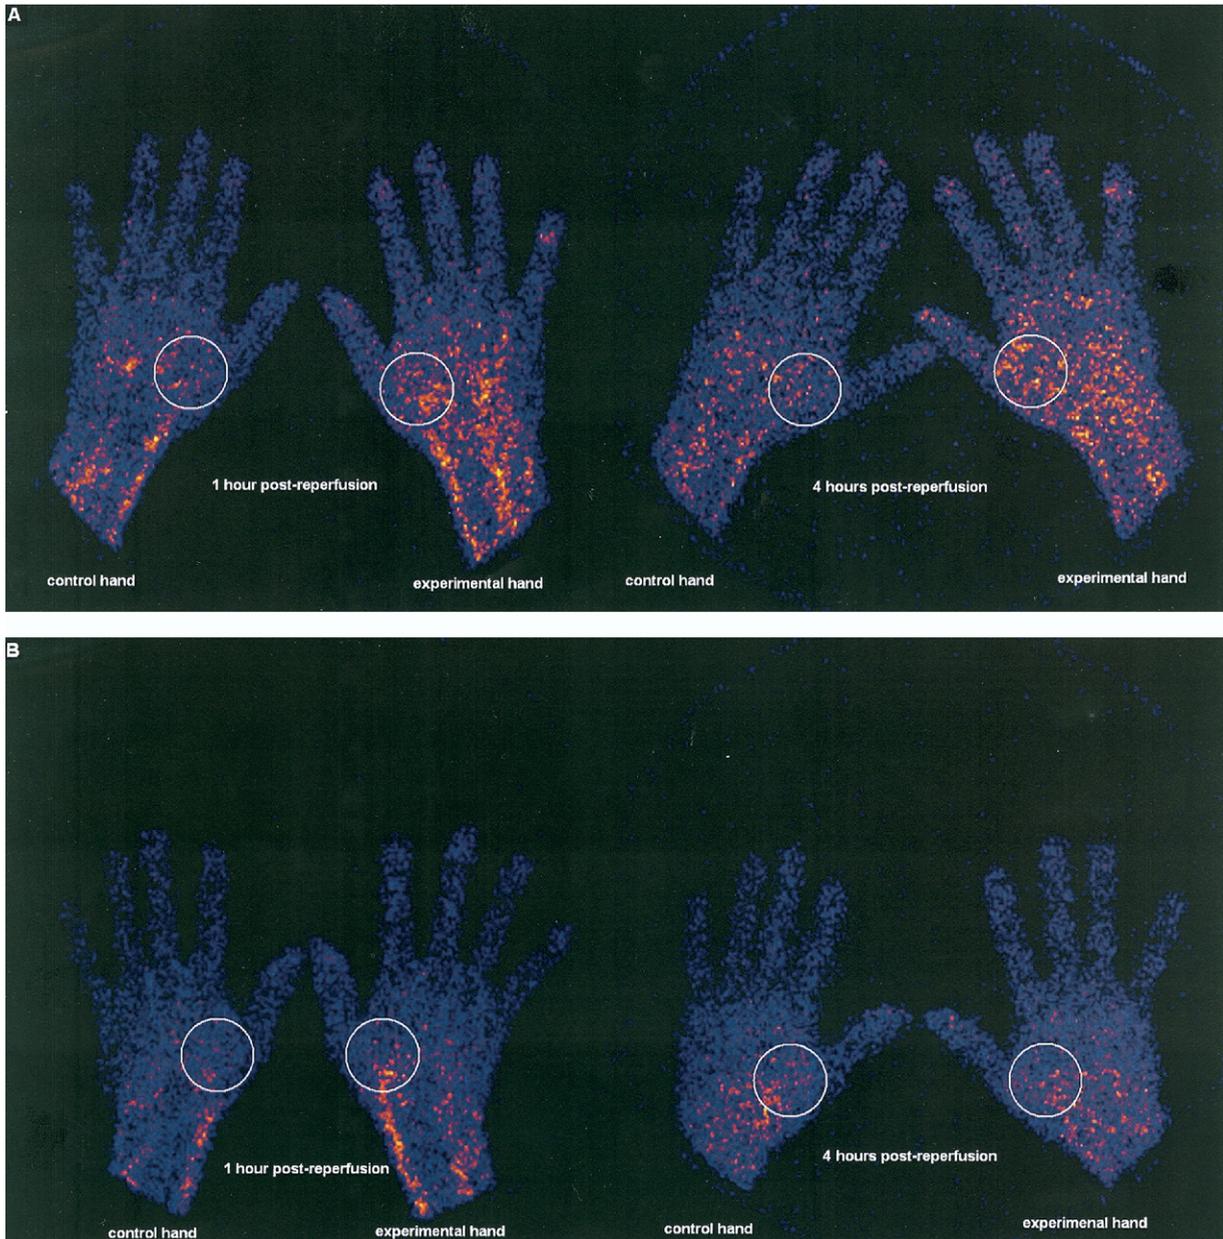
Representative scintigraphic images of the experimental and control hands at 1 and 4 h after reperfusion in preconditioned subjects pre-treated with caffeine (A) and saline (B). Annexin targeting was 2% and 3% after saline administration (saline-ischemic preconditioning-ischemic exercise) and 19% and 27% after caffeine administration (caffeine-ischemic preconditioning-ischemic exercise) at 1 and 4 h, respectively.
